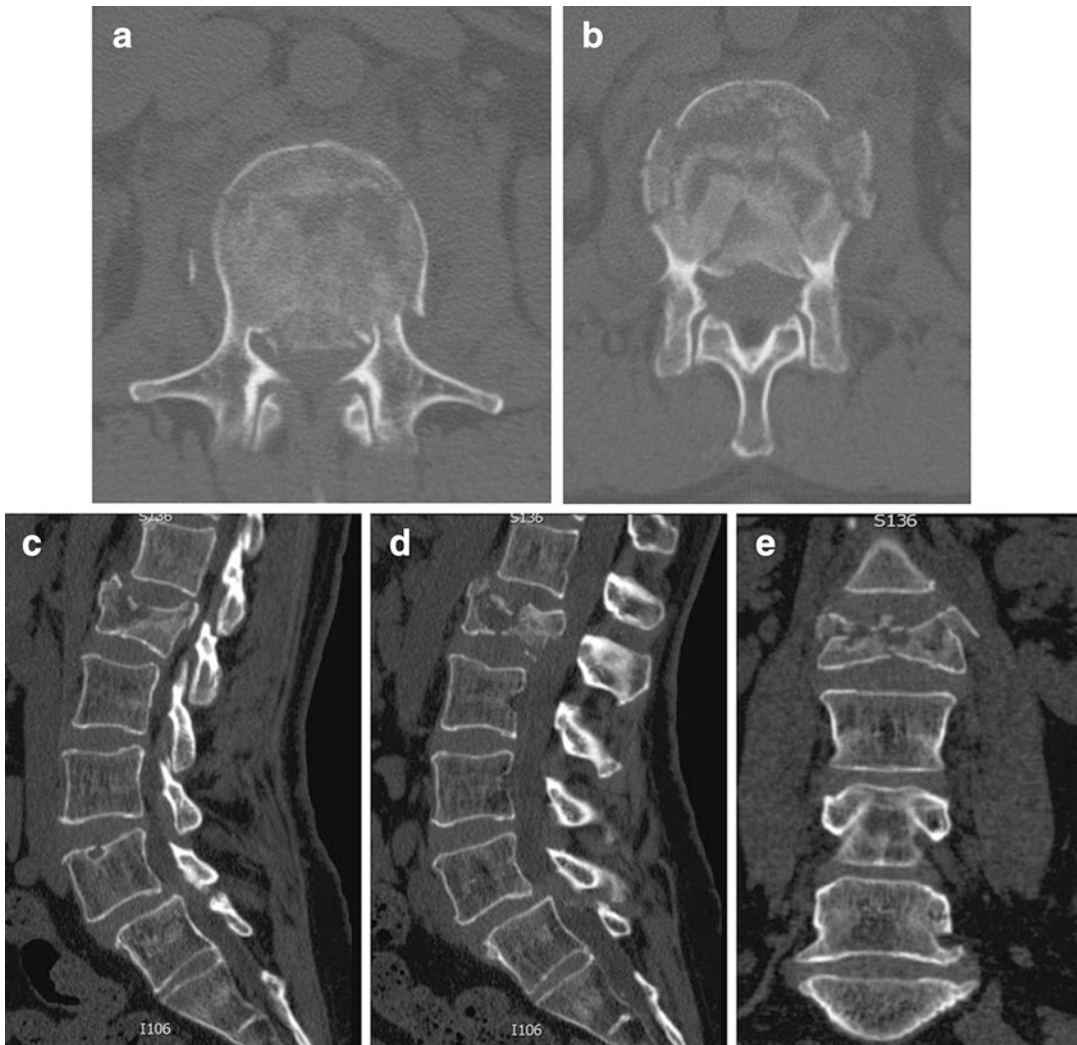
(a, b) Axial CT of the spine. (c, d) Parasagittal CT of the spine. (e) Coronal CT of the spine
